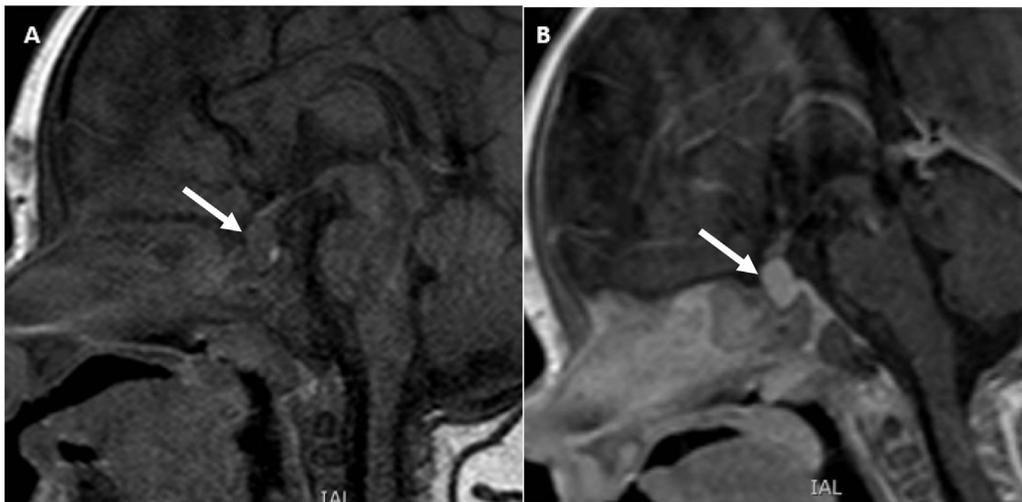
Magnetic resonance imaging at age three months. T1 noncontrast (A) and T1 postcontrast (B) with arrows showing an enhancing, T1-isointense, sellar and suprasellar mass.
